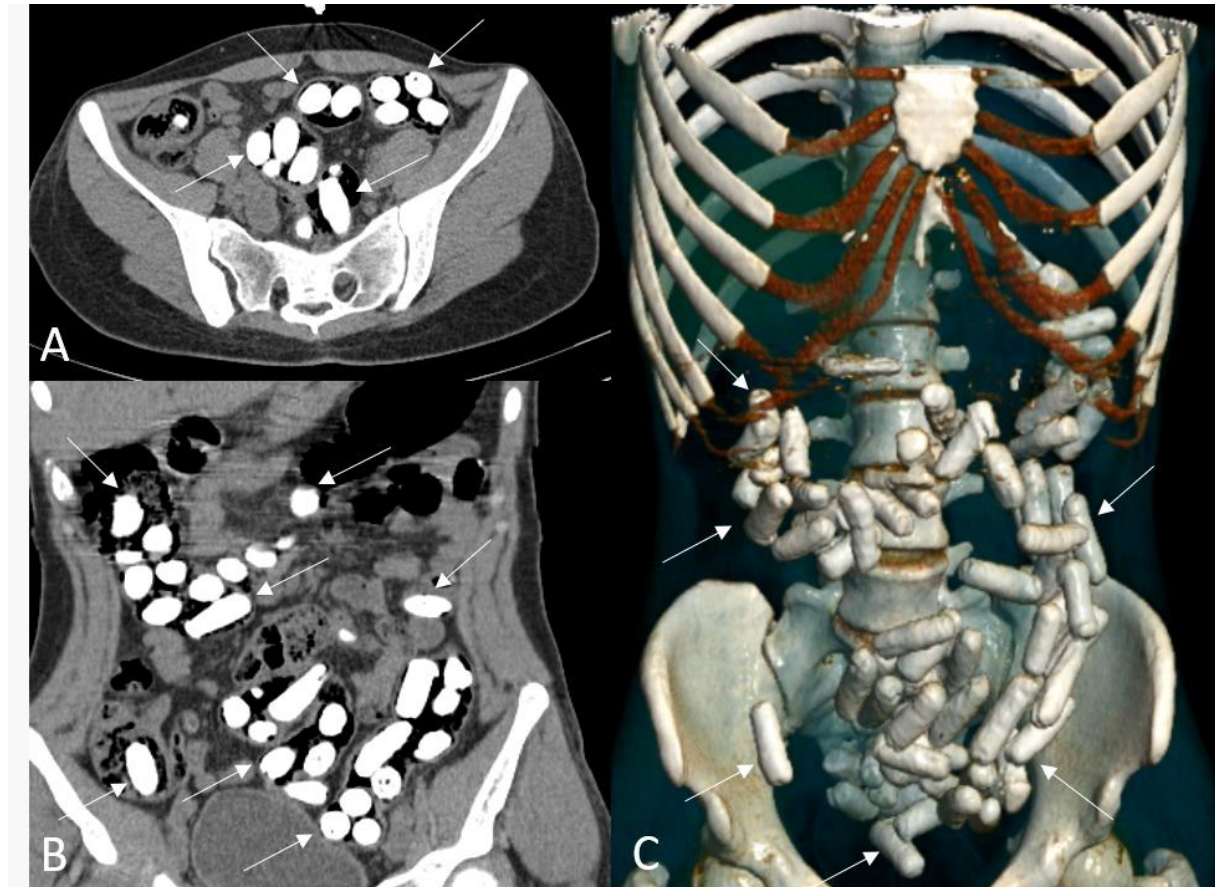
A 23-year-old female body packing case. A) Axial non-contrast abdominal computed tomography (CT) image shows multiple opaque foreign bodies (arrows) within the colon segments. B) Multiple opaque foreign bodies (arrows) are seen in all colon segments in coronal cross-sectional images. C) Opaque foreign bodies in the colon segments are seen on 3D reconstructive CT images (arrows).
